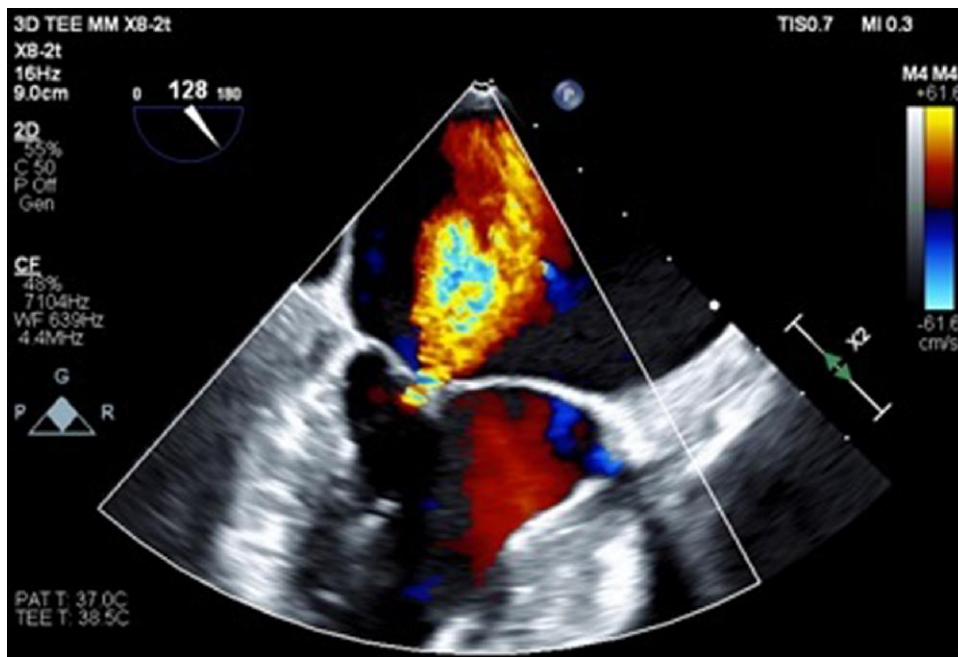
Echocardiogram—parasternal long-axis view—severe mitral regurgitation.
